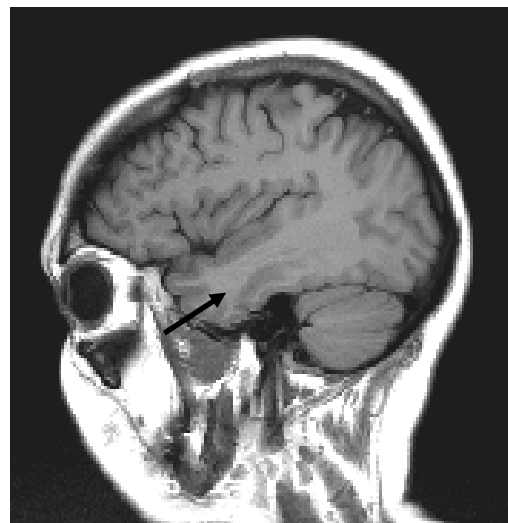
Magnetic Resonance Image Showing the Temporal Lobe (see Arrow). Adapted from “Magnetic Resonance Imaging Cross-Sectional Anatomy Technologist Educational Program” by L. Hoisington and S. Fedewa, 2007, p. 22.
